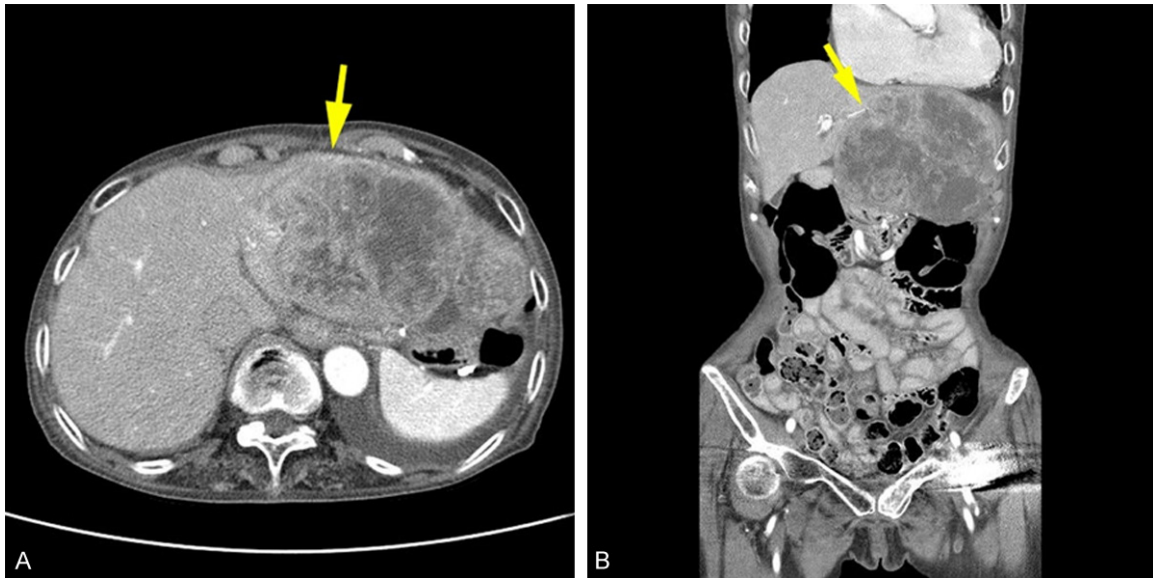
A: Contrast-enhanced computed tomography revealing an exophytic heterogeneously enhancing mass with internal necrosis in left liver. Presence of beak sign (arrow) and suggests that the lesion is arising from liver. B: Coronal image demonstrated the left hepatic artery supplying the mass (arrow) which confirms the organ of origin.
